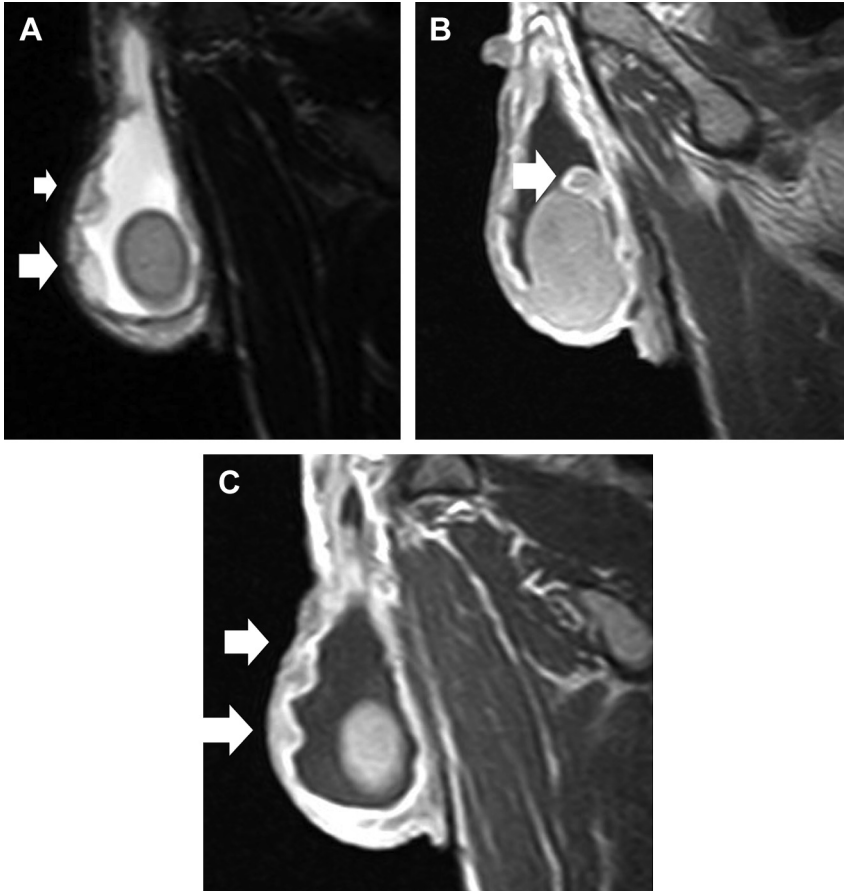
Paratesticular metastases from low-grade adenocarcinoma in a 54-year-old man. Sagittal (A) T2 and (B, C) fat-suppressed postcontrast T1-weighted images show large right hydrocele and multiple nodular small-sized masses in the paratesticular space (*arrows*). The lesions have signal intensity similar to that of normal testis on T2-weighted image and enhance strongly after gadolinium administration.
